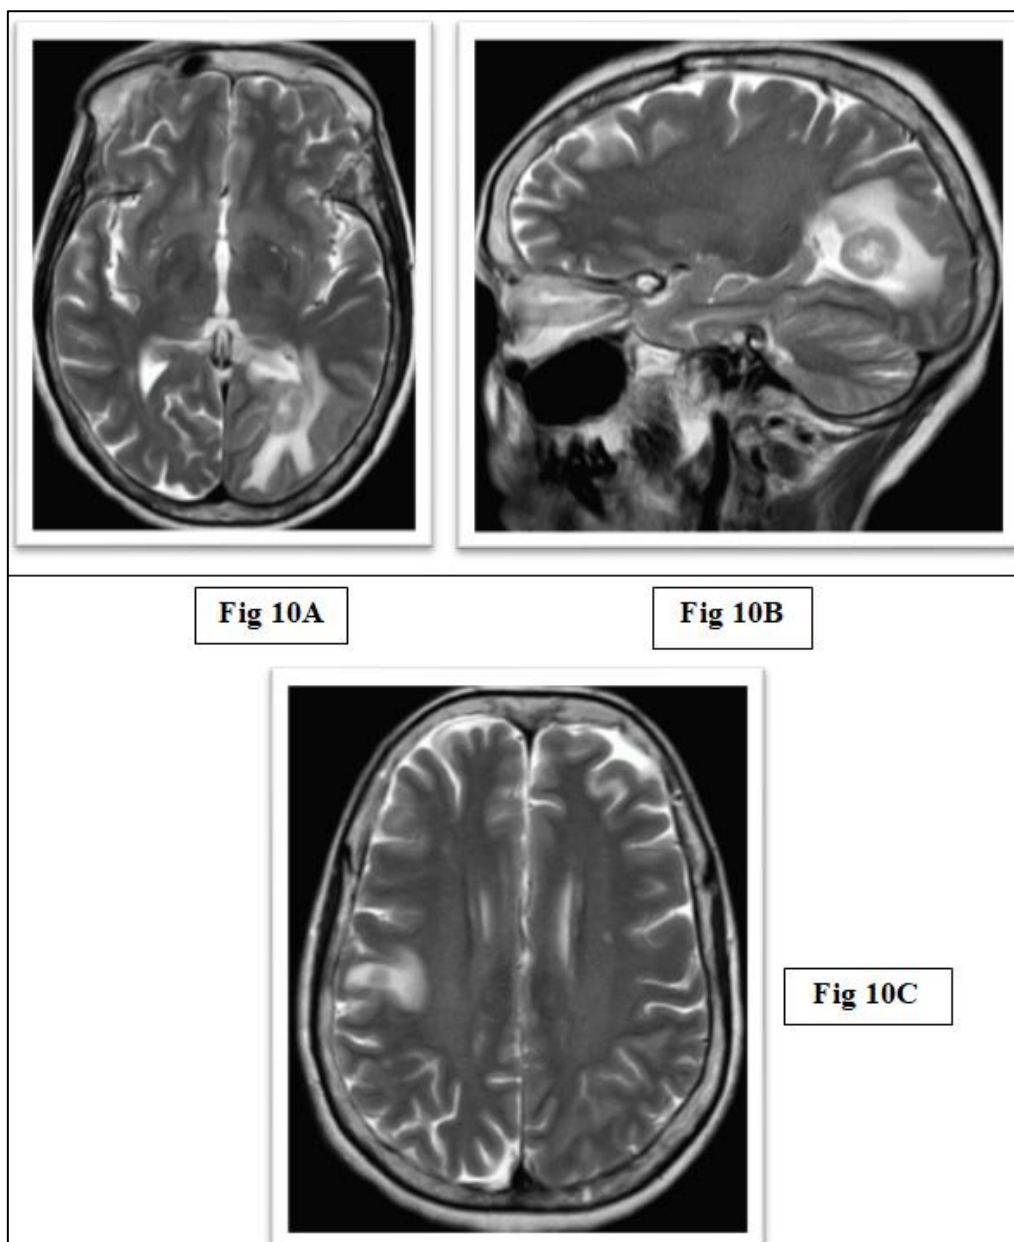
A , B : Axial and Sagittal Sections MRI Brain Showing Focal Lesions with Disproportionate Perilesional Edema in Left Occipital Lobe and in Right Parietal Lobe - Consistent with Brain Metastasis
